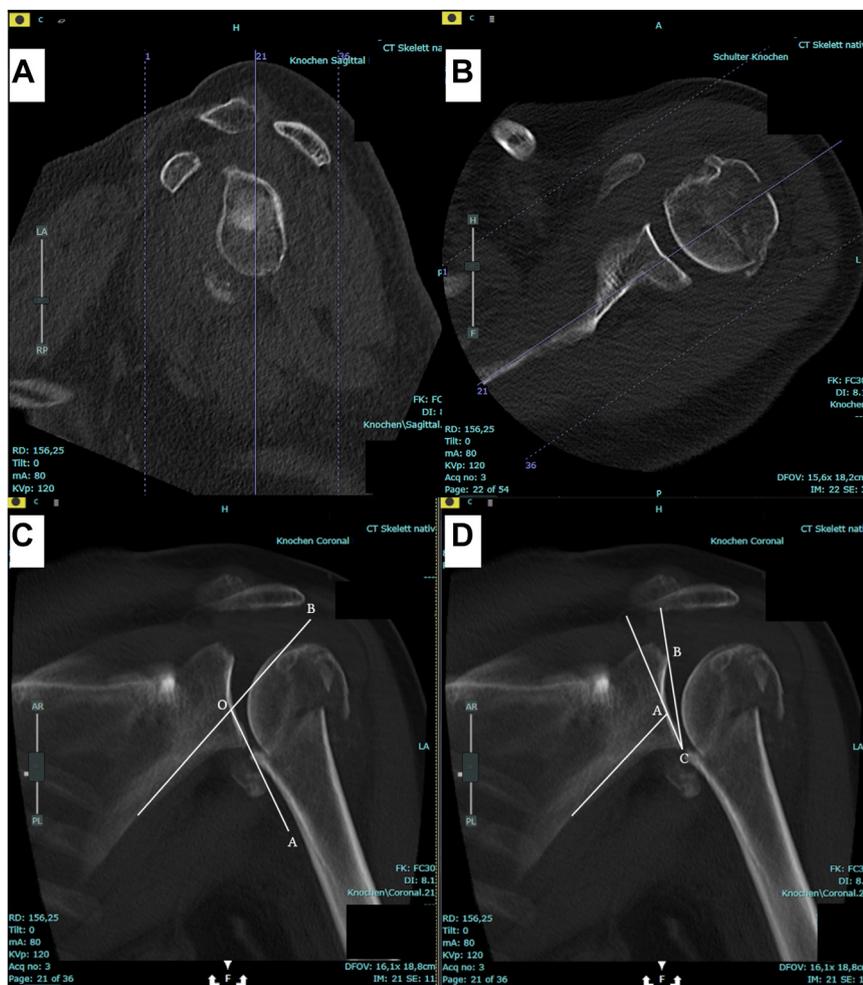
Preoperative 2-dimensional computed tomography of an 84-year-old male patient with multifragmentary proximal humerus fracture, exhibiting maximum glenoid surface on the sagittal view (A), Gantry projected along the corpus scapulae on the axial view (B), Measurement of the BOA/BCA on the coronal view (C, D).
